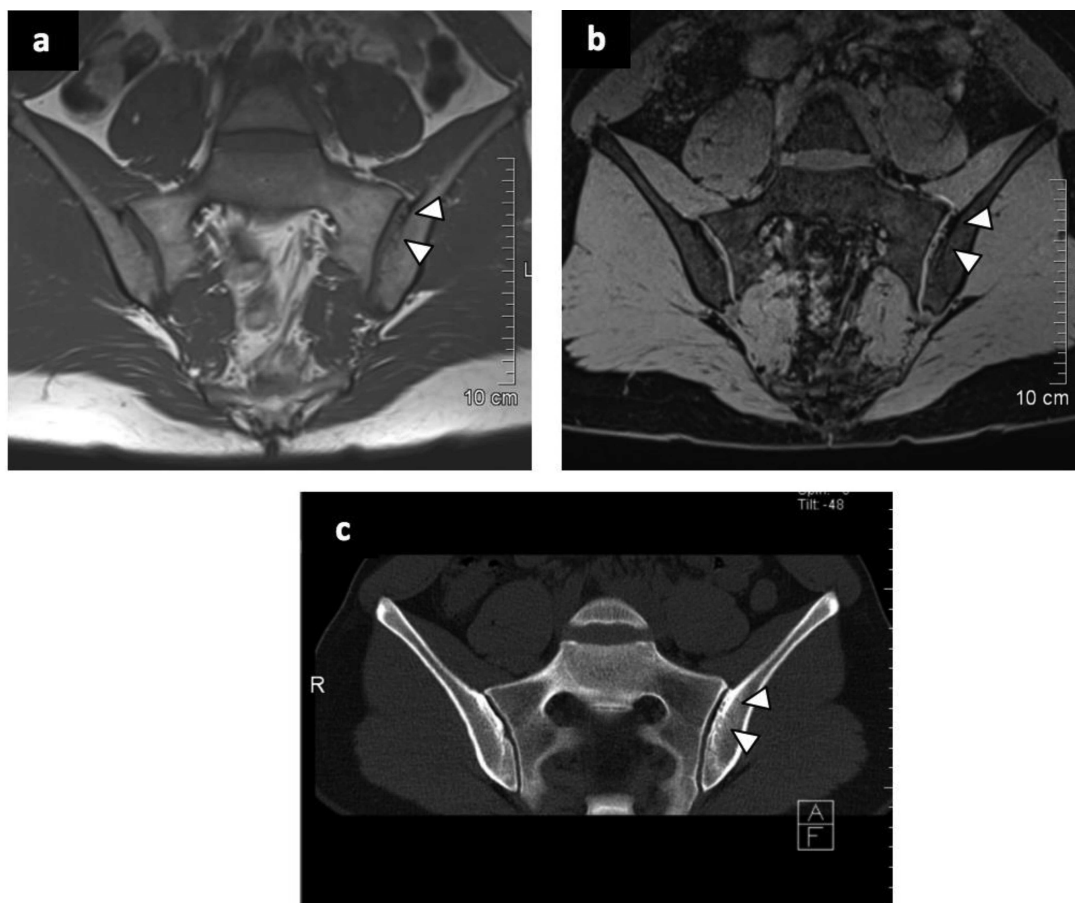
Similarities between MRI and CT. SIJ-MRI of a 45-year-old patient with axial spondyloarthritis. A. T1-weighted MRI sequence. B. VIBE sequence. C. CT in the semicoronal view. Arrowheads indicate erosions, seen on both MRI sequences and the CT scan. VIBE: volumetric interpolated breath-hold examination; MRI: magnetic resonance imaging; CT: computed tomography; SIJ: sacroiliac joints.
